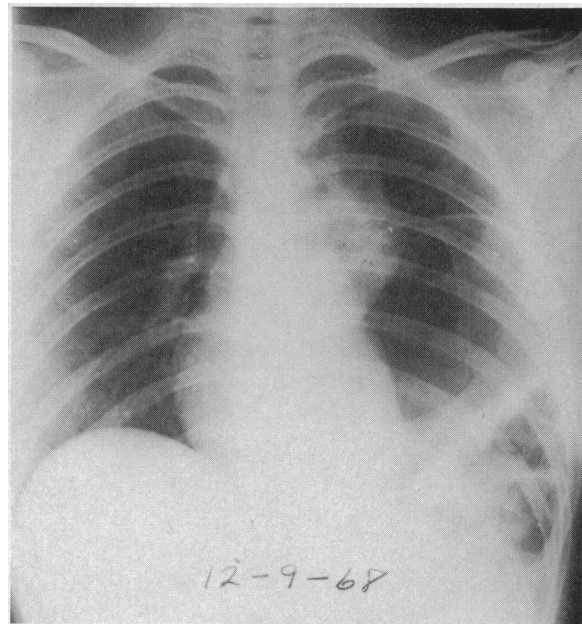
X-ray film taken after aspiration of air and introduction of nasogastric tube shows mediastinum returned to midline, left lung expanded superiorly and a gas-filled viscus (containing loop of tube) in left hemithorax.
